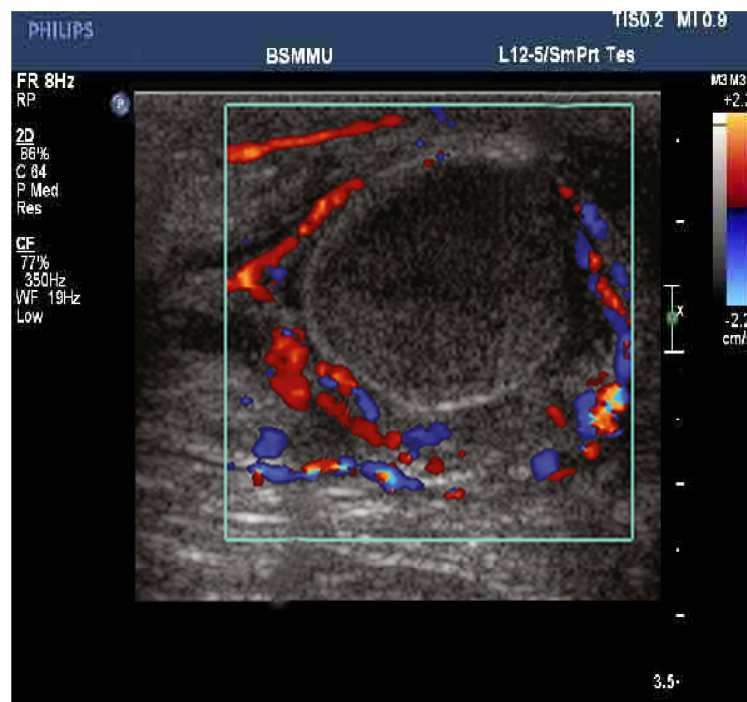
Testicular torsion- Color Doppler scan showing absent vascularity within testis with increased peripheral vascularity.
